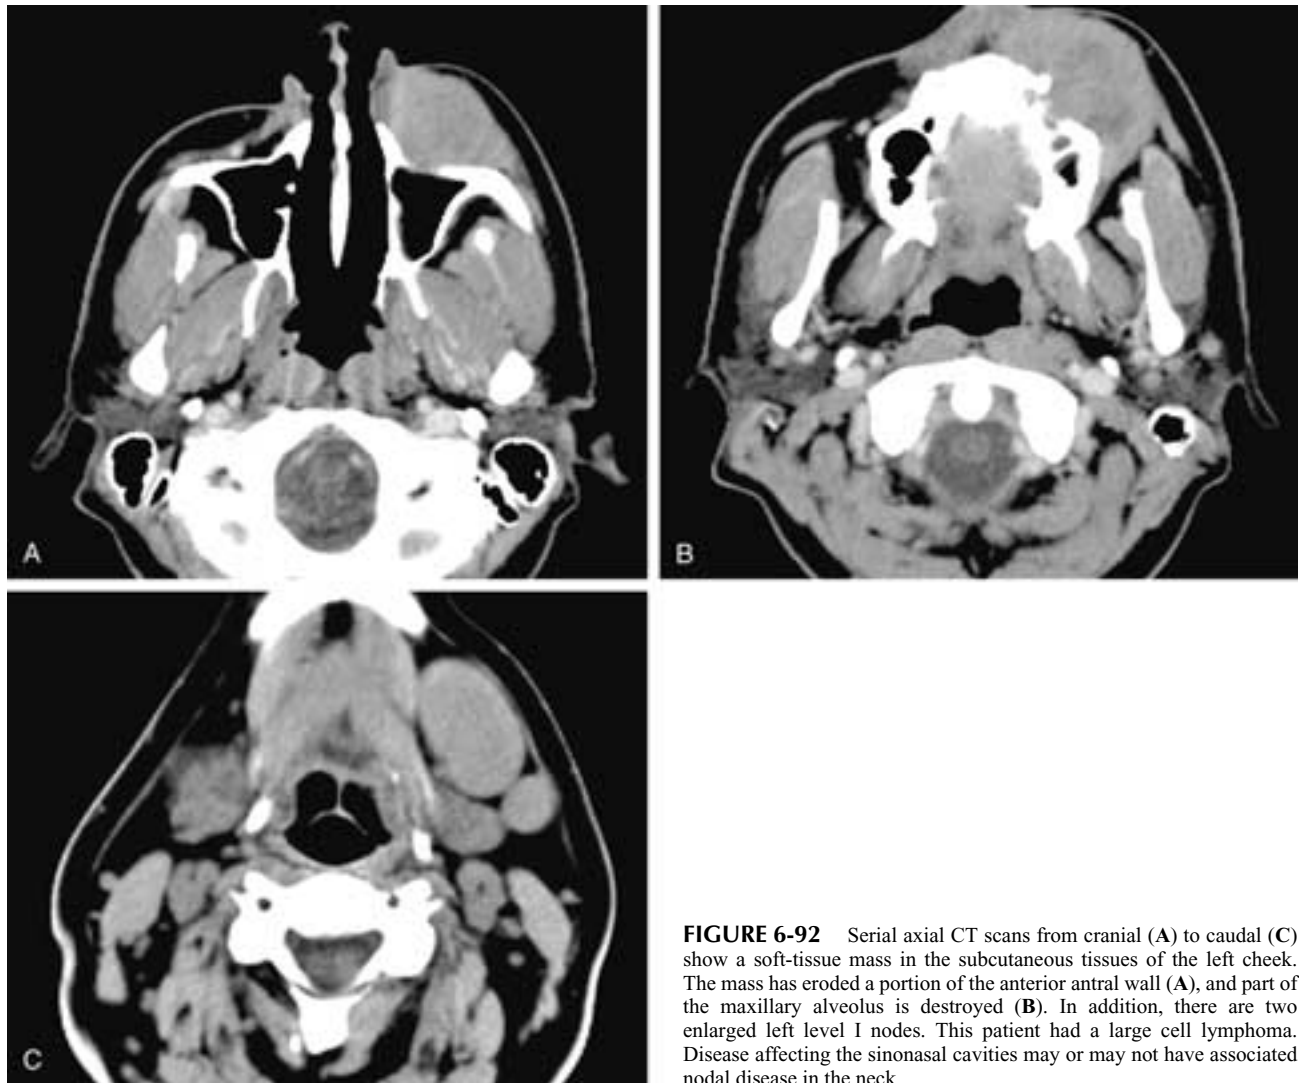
Serial axial CT scans from cranial (A) to caudal (C) show a soft-tissue mass in the subcutaneous tissues of the left cheek. The mass has eroded a portion of the anterior antral wall (A), and part of the maxillary alveolus is destroyed (B). In addition, there are two enlarged left level I nodes. This patient had a large cell lymphoma. Disease affecting the sinonasal cavities may or may not have associated nodal disease in the neck.
